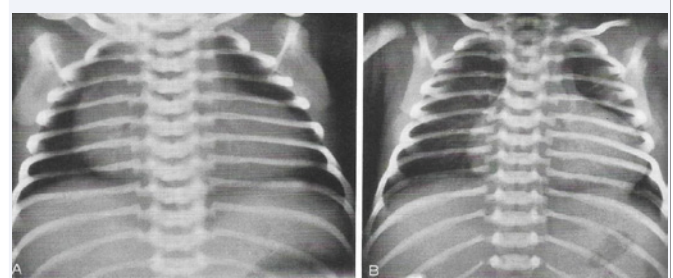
Chest X-rays (postero-anterior views) of two neonates with Ebstein's anomaly. A shows moderate to severe cardiomegaly secondary to right atrial enlargement. B shows mild cardiomegaly. The pulmonary vascular markings appear markedly decreased in both A and B. Reproduced from Reference [2].
